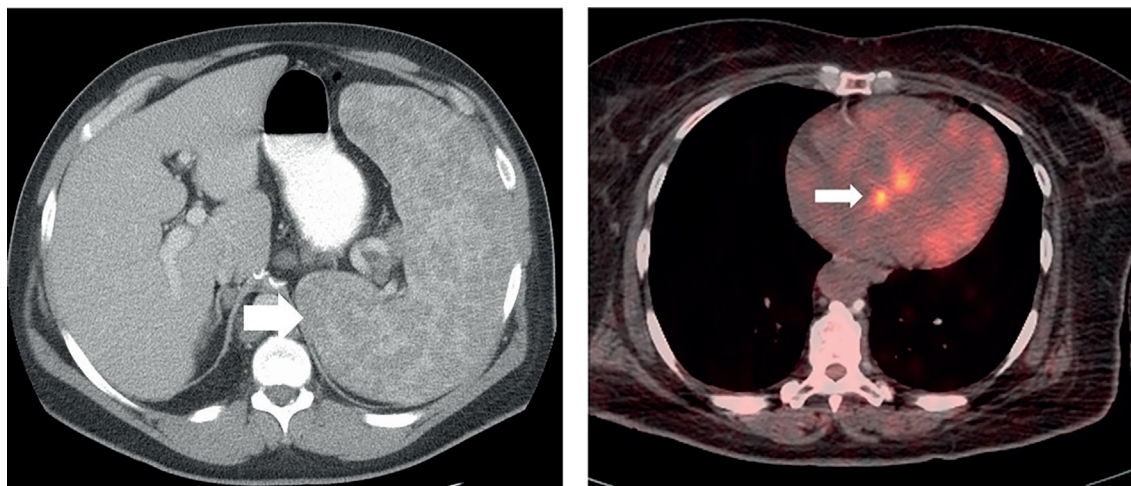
Two examples of at least probable organ involvement (4). On left is the CT image of the spleen showing infiltration by lower density areas (arrow). On right, increased FDG PET activity is seen in the septum of heart (arrow). Each of these would be worth two points for the SDS score.
